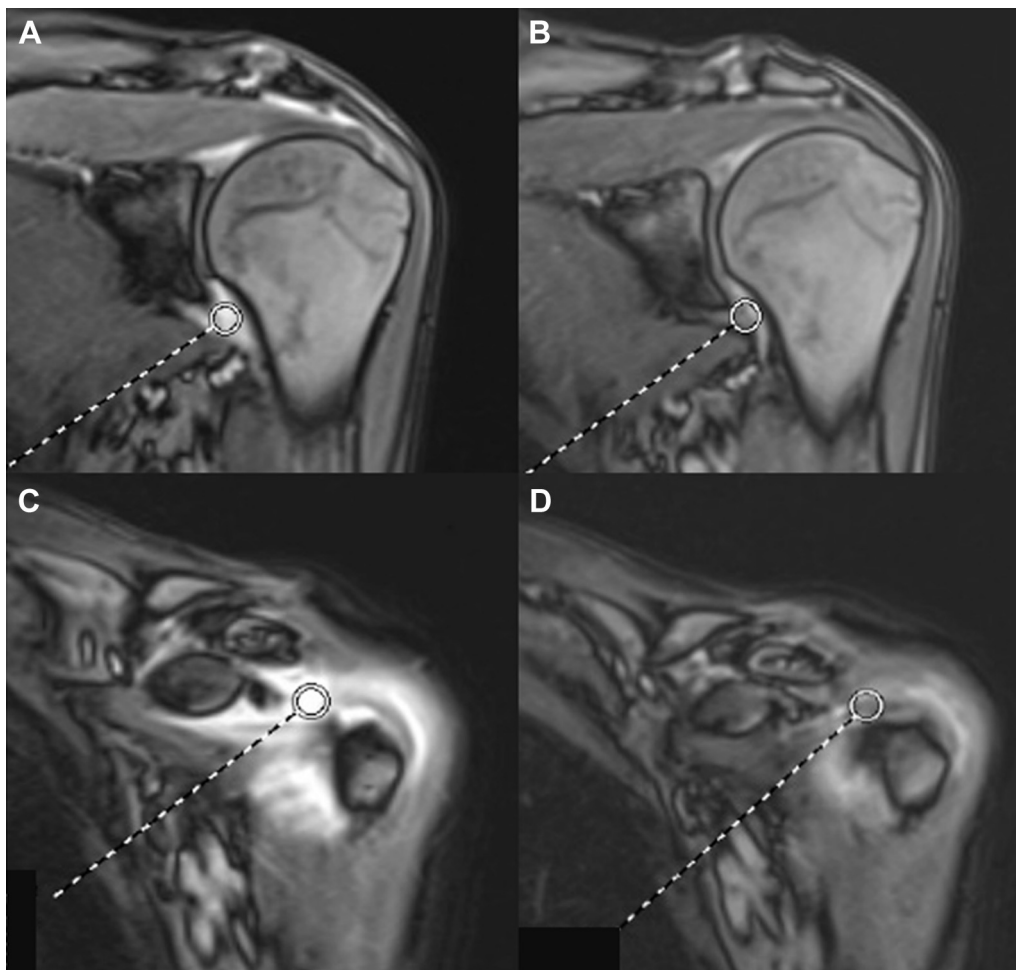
Measurement sites of the AP and RI with dynamic MRI. The measurement sites were determined within the contrast range of the AP and RI by the 0.3-cm² ROI (white circle). (A) is the measured signal intensity within the AP before MUC, (B) is the measured signal intensity within the AP after MUC, (C) is the measured signal intensity within the RI before MUC, and (D) is the measured signal intensity within the RI after MUC. MRI, magnetic resonance imaging; MUC, manipulation under ultrasound-guided cervical nerve root block; AP, axillary pouch; RI, rotator interval; ROI, region of interest.
